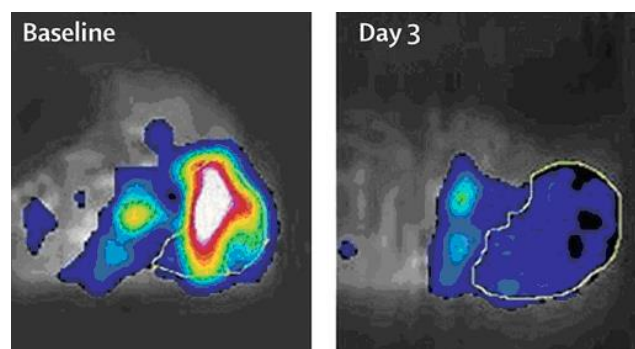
ASL MRI shows decreased perfusion on day 3. Courtesy of Schor-Bardach et al. (71)
